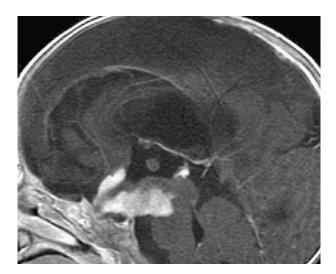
Postgadolinium, sagittal T1-weighted magnetic resonance imaging reveals an optic pathway glioma and resultant obstructive hydrocephalus.
